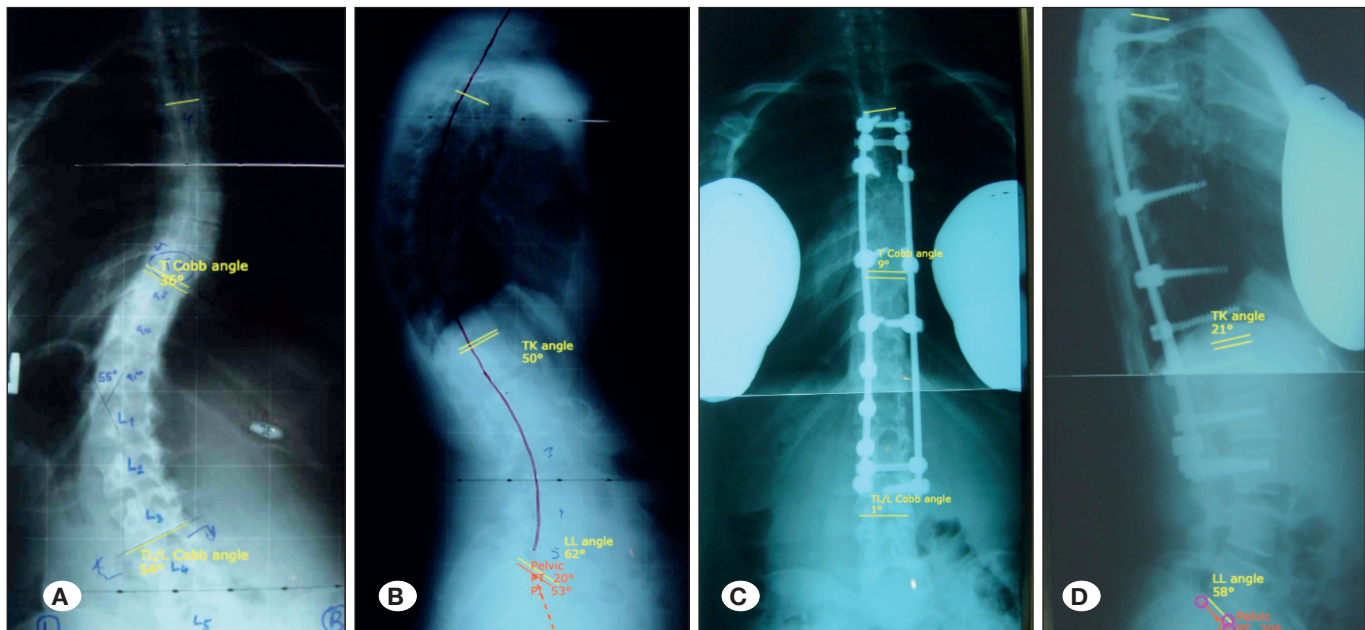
Preoperative (A,B) and 37-month follow-up radiographs (C,D) of a 25-yr-old female patient with a 54° TL/L Cobb angle, 36° T Cobb angle, and 50° T hyperkyphosis were corrected by nonselective fusion procedure. TL/L Cobb, T Cobb, and T kyphosis were 1° , 9° , and 21° , respectively.
